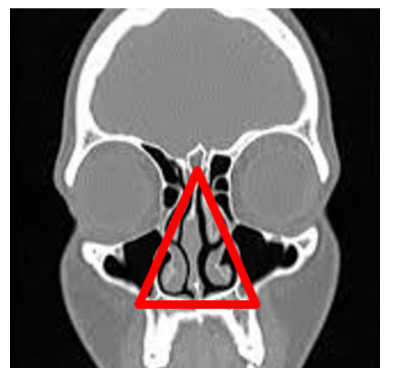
CT scan showing nasal passage
